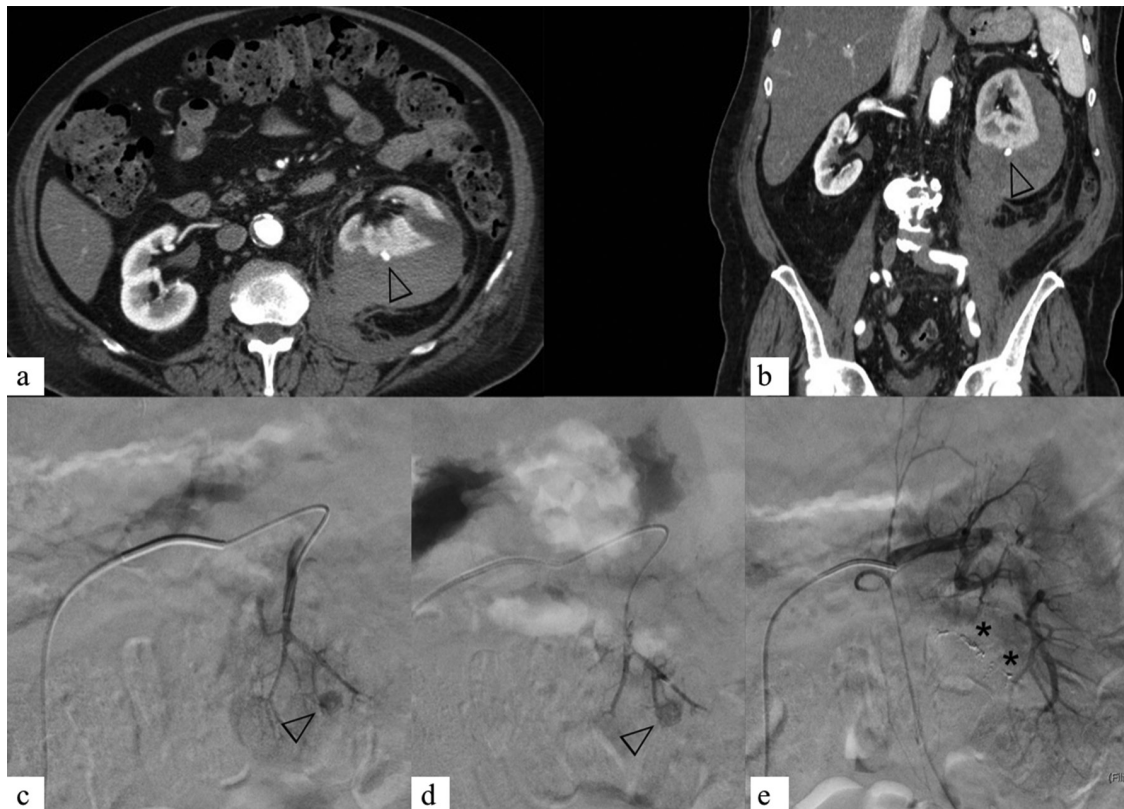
(a, b) Axial and coronal MPR CT images showing active spontaneous bleeding in an uncoagulated patient originating from a small pseudoaneurysm located between interlobular and arcuate renal arteries (arrowhead). (c, d) The same bleeding is clearly shown after superselective catheterization using a 2.8F DMSO-compatible coaxial microcatheter system (arrowhead; Progreat, Terumo Interventional Systems). (e) After successful embolization, a single shot confirms the presence of Onyx (asterisk).
